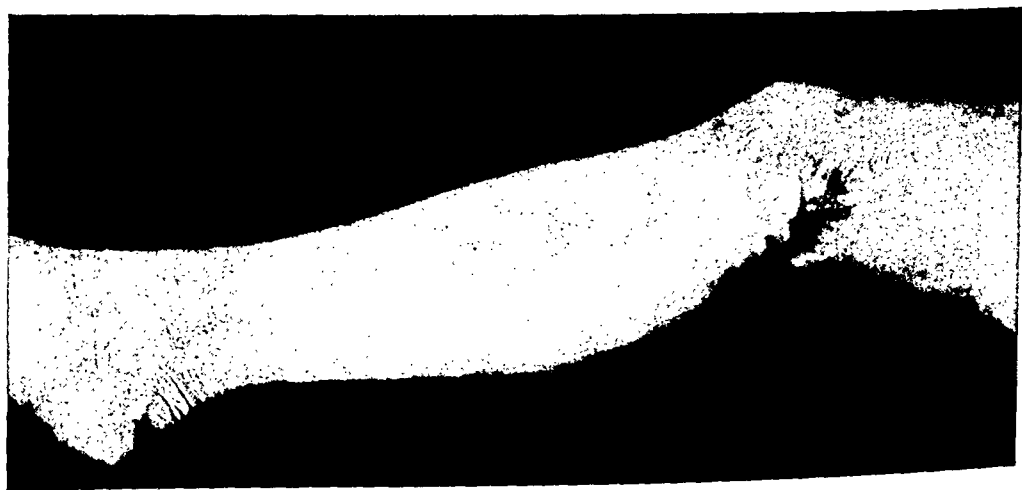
Photographs and X-rays of Case No. IV described in the text. The X-rays were taken immediately before and twenty-four hours after operation. Photograph indicates the result at the end of eighteen months.
